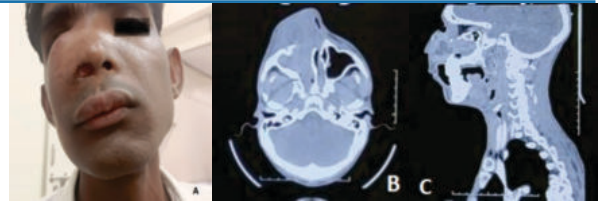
(A) External facial Appearance, (B) CT PNS Axial cut showing subcutaneous involvement and erosion of anteromedial wall of right maxilla. , (C) CT PNS Saggital cut showing soft tissue mass lesion at nasopharynx
